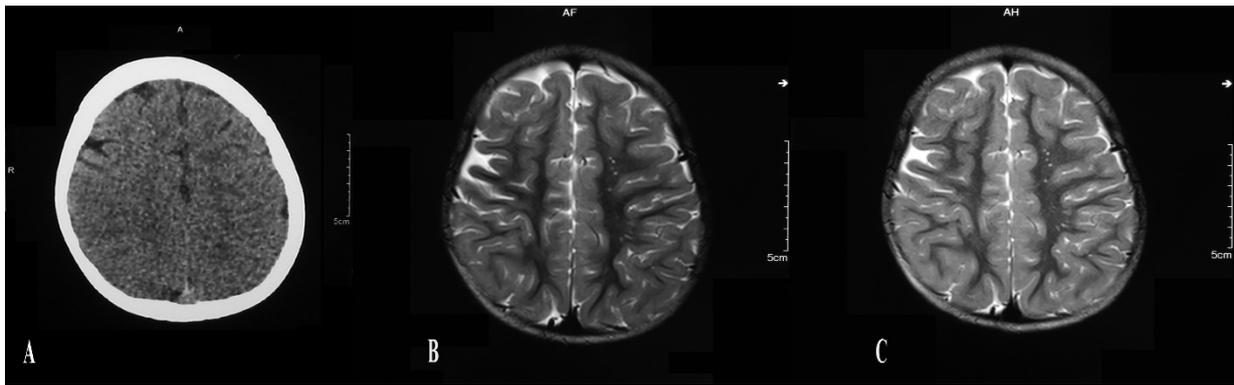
(A) Initial axial non-enhanced brain CT scan showing focal cortical atrophy at the right superior fronto-parietal lobe without calcifications
